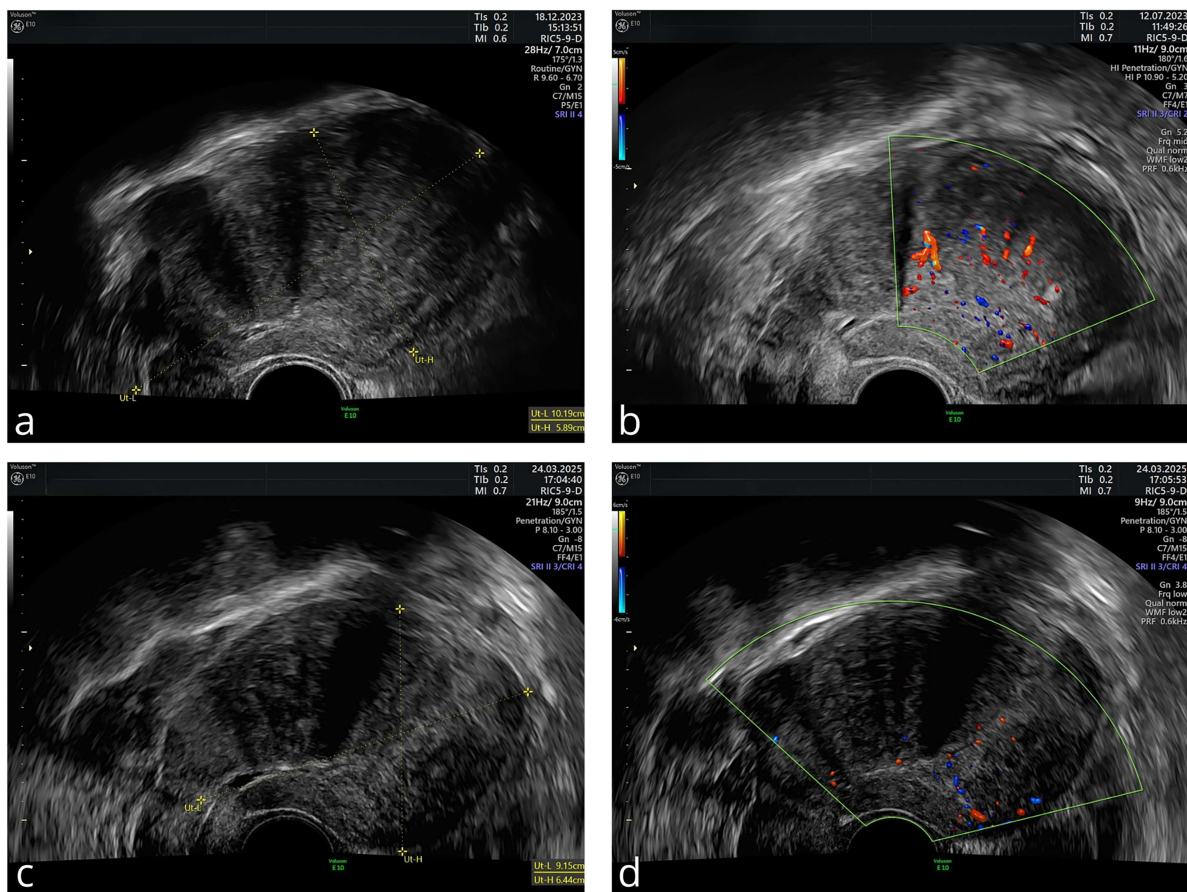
Transvaginal ultrasound evaluation of the uterus in Case 3. (a) Baseline grayscale image showing an enlarged globular uterus with anterior wall thickening and heterogeneous myometrial echotexture. Direct signs of adenomyosis are visible, including hyperechogenic islands, echogenic sub endometrial lines and buds, and small myometrial cysts. (b) Baseline color Doppler image demonstrating marked translesional vascularity (color score 3). (c) Follow-up grayscale ultrasound at 12 months showing a reduction in uterine volume and slightly improved homogeneity of the myometrial texture. (d) Follow-up Doppler image revealing decreased vascularization (color score 2) after 12 months of therapy.
